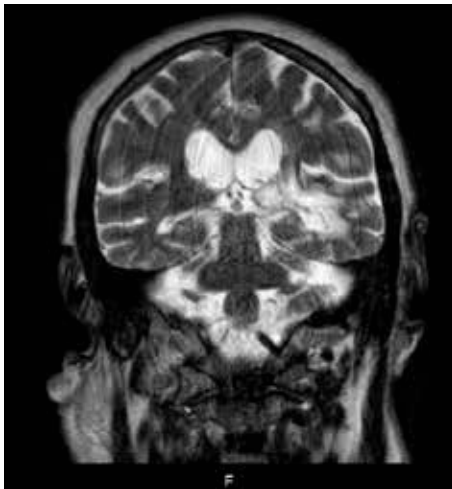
Magnetic resonance imaging of brain of Patient #1 showing stable surgical and post-radiation treatment related changes, without evidence of acute process or recurrent malignant disease.
